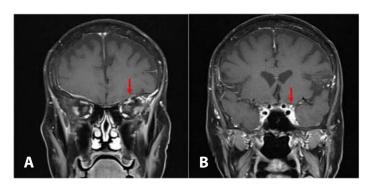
A) Abnormal enhancement of the ophthalmic branch of the trigeminal nerve (red arrows) as it passes through the orbit, and B) asymmetric fullness within the cavernous sinus seen on MRI.
